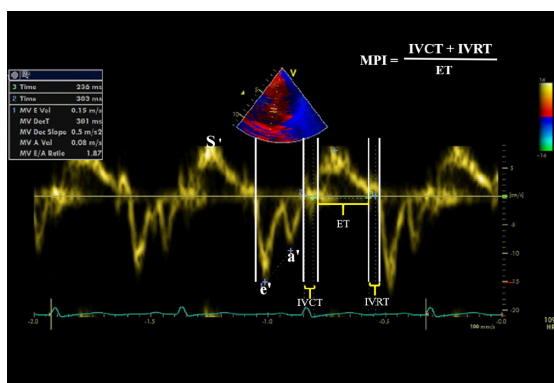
Tissue Doppler echocardiography of septal annulus showed the main tissue waves (S, e' and a' waves) and how to calculate Myocardial Performance Index. e' and a' Early and late filling waves by tissue Doppler; S wave: Myocardial systolic excursion velocity. IVCT: Isovolumic contraction time; IVRT: Isovolumic relaxation time; MPI: Myocardial Performance Index; ET: Ejection time.
